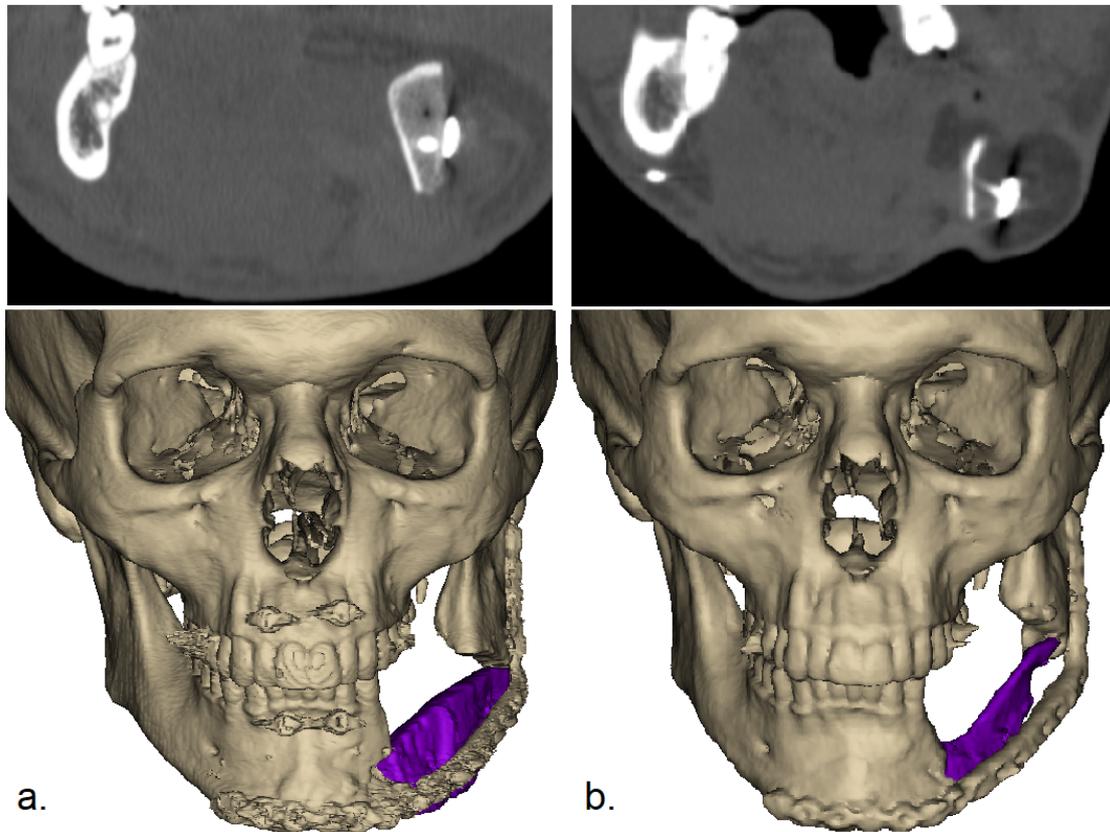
Graft volumetric changes on CT imaging and 3D reconstruction (Mimics Medical 23.0 software): (a) postoperative (initial) graft volume, (b) graft volume at the 9-month follow-up.
